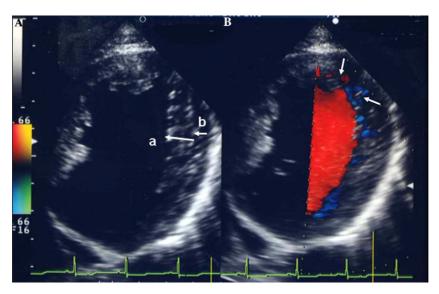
(A) Two-dimensional echocardiogram of a patient with LVNC demonstrating the two-layer structure of noncompacted (a) and compacted (b) layers, a/b > 2.0. (B) Color Doppler echocardiogram of a patient with LVNC demonstrating flow within deep intertrabecular recesses (arrow) in continuity with the left ventricular cavity.
